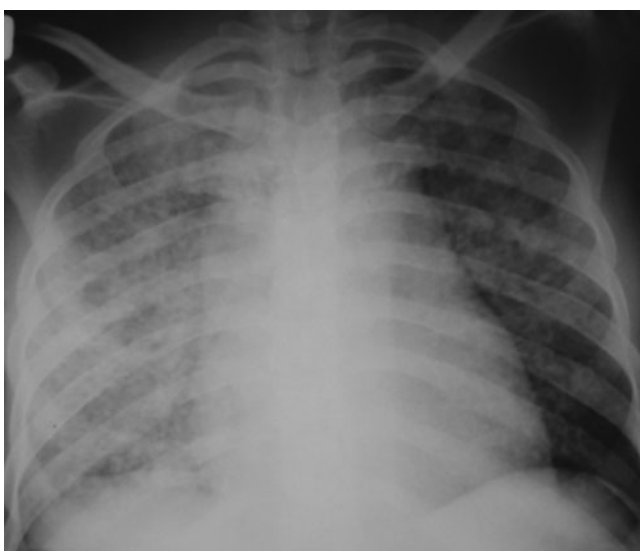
Miliary tuberculosis in a patient with a CD4+ T-cell count of 4 cells mm⁻³. Anteroposterior chest radiograph shows innumerable small discrete nodules 1–2 mm in diameter, diffusely distributed throughout both lungs.
